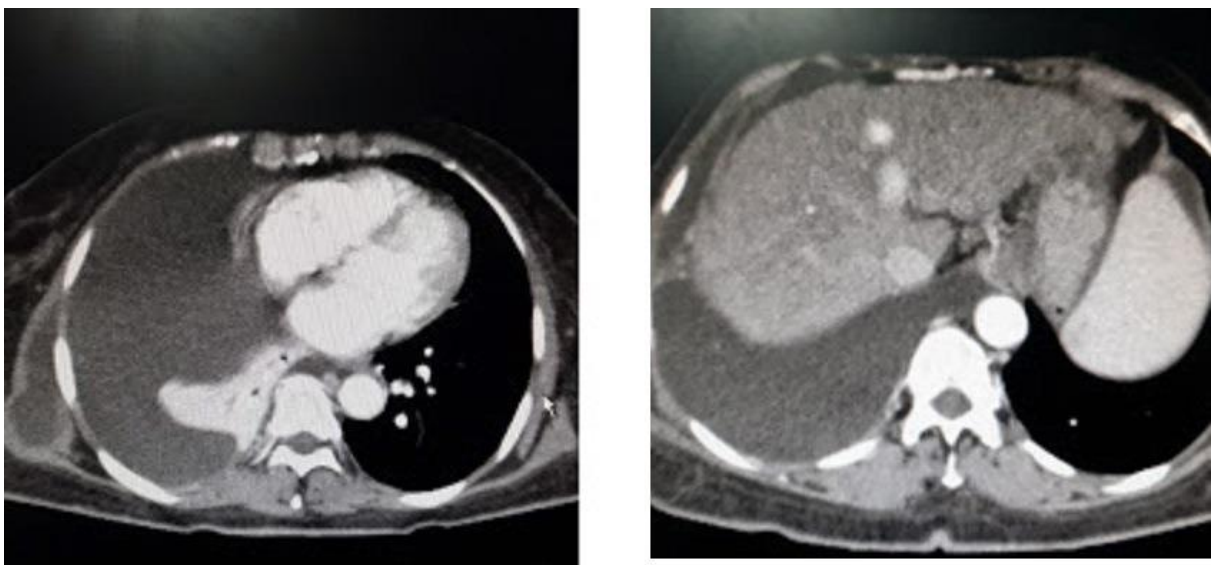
Computed tomography imaging liver parenchyma and pleural effusion
